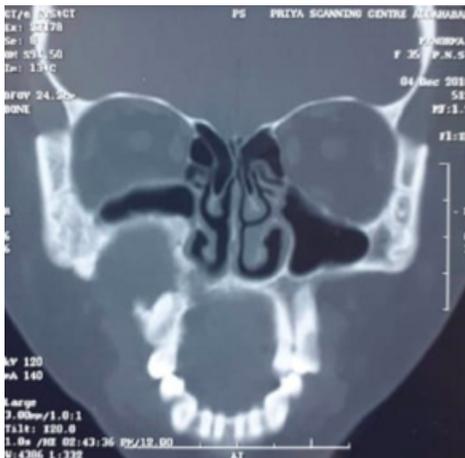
CT scan Bone window (coronal section) showing destruction of the right upper alveolar margin with lifting of floor of right maxillary antrum
